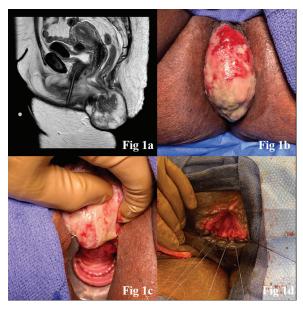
a) Sagittal view of rectal mass on MRI; b) Prolapsing rectal mass; c) EUA with patient in lithotomy position showing non-obstructing mass originating from anterior third of rectal wall; d) Patient in prone position status post closure after transanal excision.
